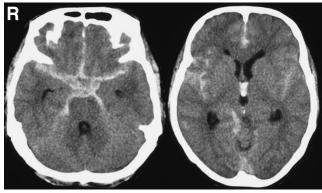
Head computed tomography scans on admission showing subarachnoid hemorrhage in the basal cisterns and bilateral sylvian fissures, but no low density area in the left internal capsule.
